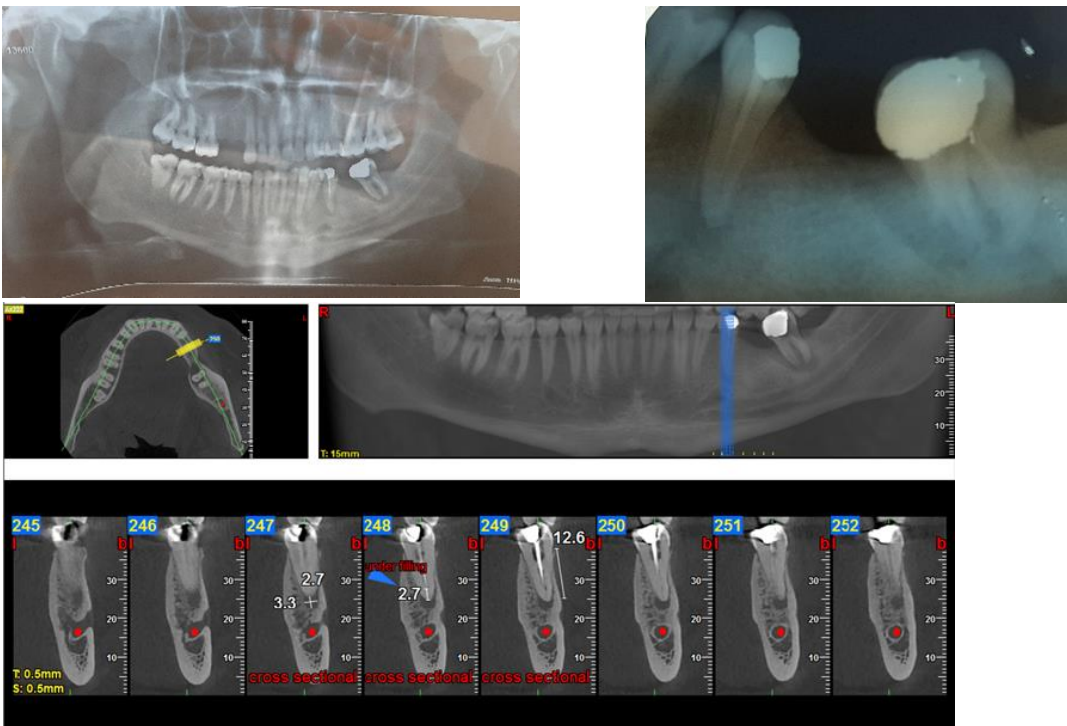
Comparison of panoramic, CBCT, and periapical radiography of tooth #20 with root canal treatment.
